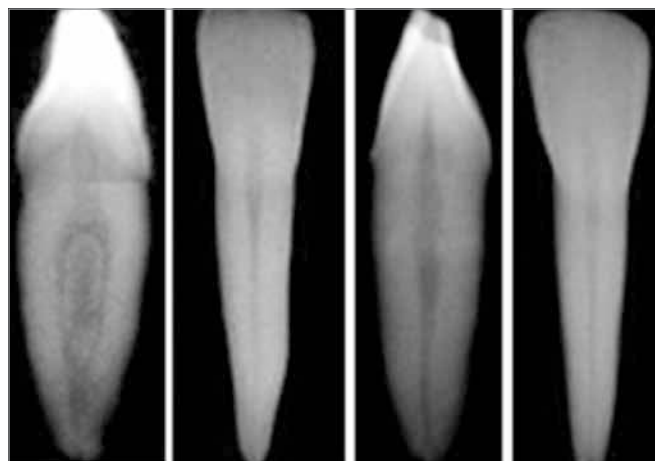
Periapical radiographs of two samples, on vestibulolingual (VL) direction and mesiodistal (MD) direction to confirm the absence of calcification as well as the number of canals.
